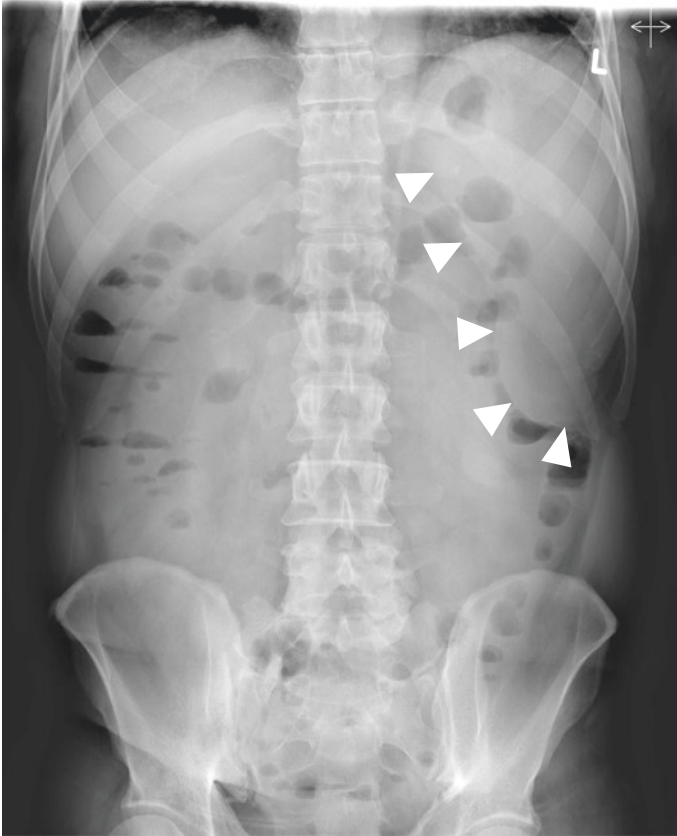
Abdominal radiograph demonstrates a soft-tissue density structure extending from the left upper quadrant and displacing the colon inferomedially, consistent with splenomegaly
